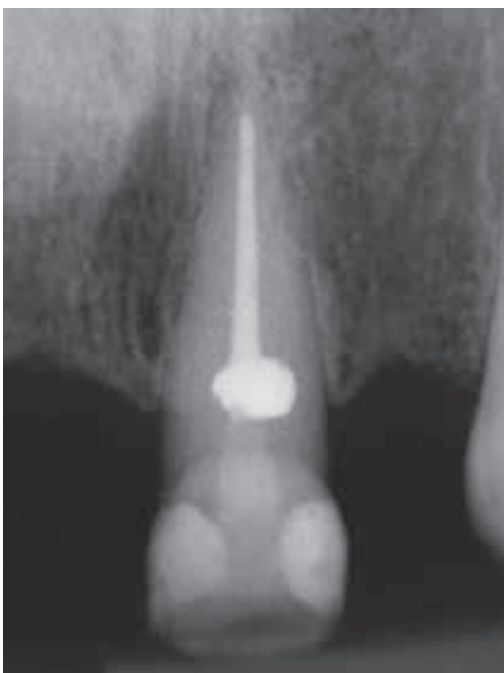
Radiographic tracing of the intraoral fistula
